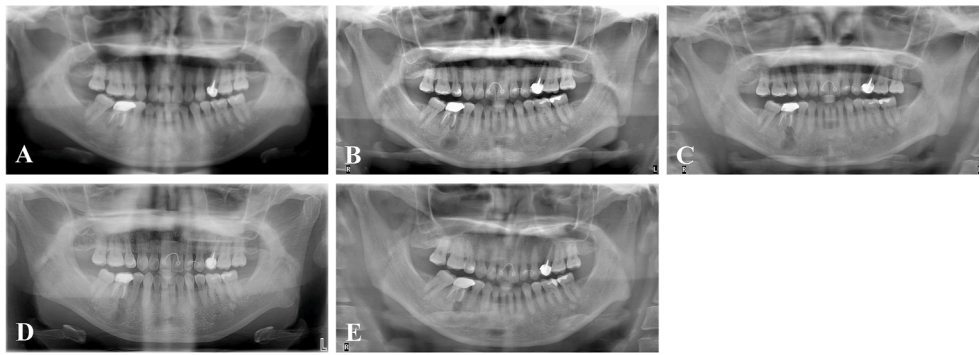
A series of panoramic radiographs of an adult female patient who was found to have a cystic lesion in the right posterior mandible and received the surgical treatment after 10 years of follow-up. (A) A cystic lesion at the periapical area of the mesial root of the tooth 46 was discovered 10 years ago, when she had a panoramic radiograph taken during her initial visit at a dental clinic. (B) The preoperative panoramic radiograph showed a radiolucent lesion at the periapical area of the mesial root of the tooth 46, and its size was larger than that found 10 years ago. (C) The postoperative panoramic radiograph showed a clear-cut radiolucent image at the periapical area of the mesial root of the tooth 46 after enucleation of the cyst. (D) The panoramic radiograph taken 2 months after the surgery showed the initial bone healing in the surgical wound area. (E) The panoramic radiograph taken 6 months after the surgery showed a marked reduction of the size of the cystic lesion postoperatively, indicating the continued bone regeneration of the postoperative cystic defect.
